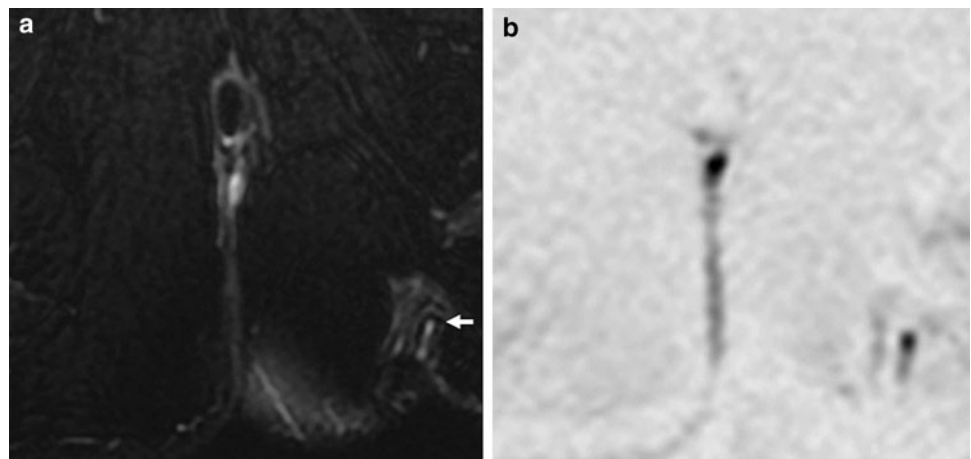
A 37-year-old man presented with a deep anal abscess. a Fat-suppressed T2WI shows that the abscess has spread deeply to involve a large area. b DWI shows active inflammation inside a deep and large abscess. DWI can be used to assess inflammatory activity and to easily define the extent of an abscess
